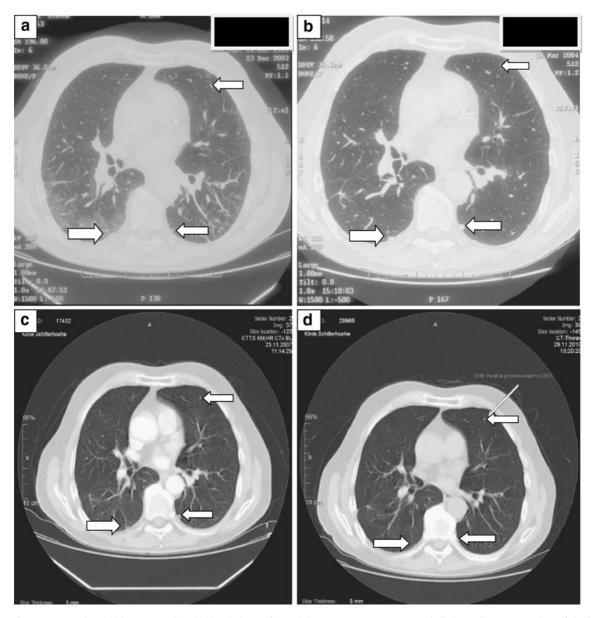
a-d From December 2003 to November 2010, all the performed CT scans over a 7-year period showed no progression of the bilateral pulmonary lesion. The bilateral pulmonary nodules were stable in terms of size, number and form
